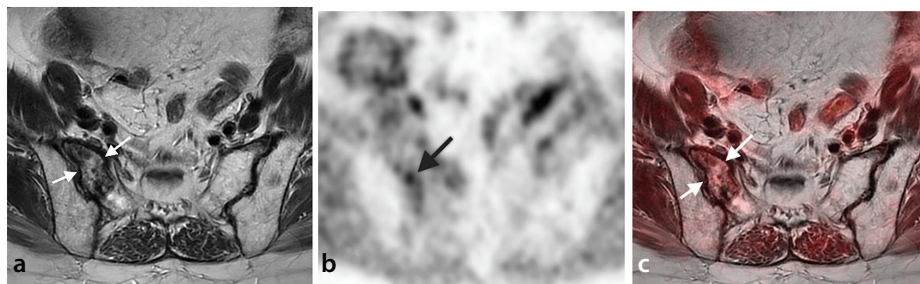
Sacral osteonecrosis following radiation therapy in a patient with cervical cancer. The axial T2-weighted magnetic resonance image (MRI) (a) shows a heterogeneous lesion of intermediate signal intensity in the sacral side of the right sacroiliac joint (arrows). The lesion is newly developed after radiation therapy. The axial positron emission tomography (PET) (b) and axial fused PET/MRI (c) show moderate fluorodeoxyglucose activity (arrows) in the osseous lesion.
